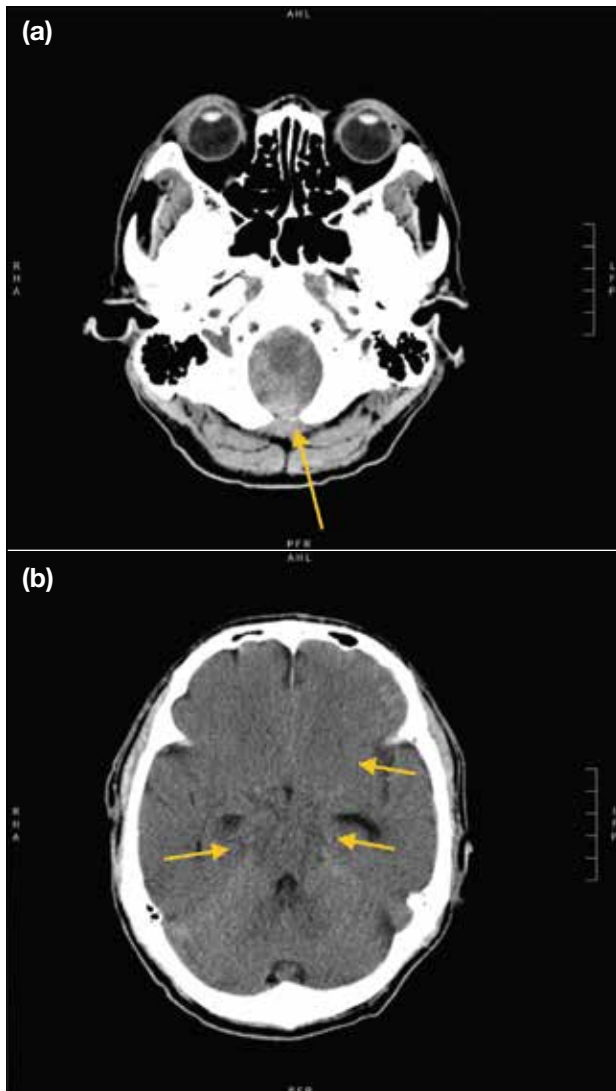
Non-contrast computed tomography of the brain at the level of foramen magnum (a) and basal cisterns (b). Subarachnoid haemorrhage is shown (arrows), predominantly in the posterior cranial fossa, especially at the foramen magnum.
